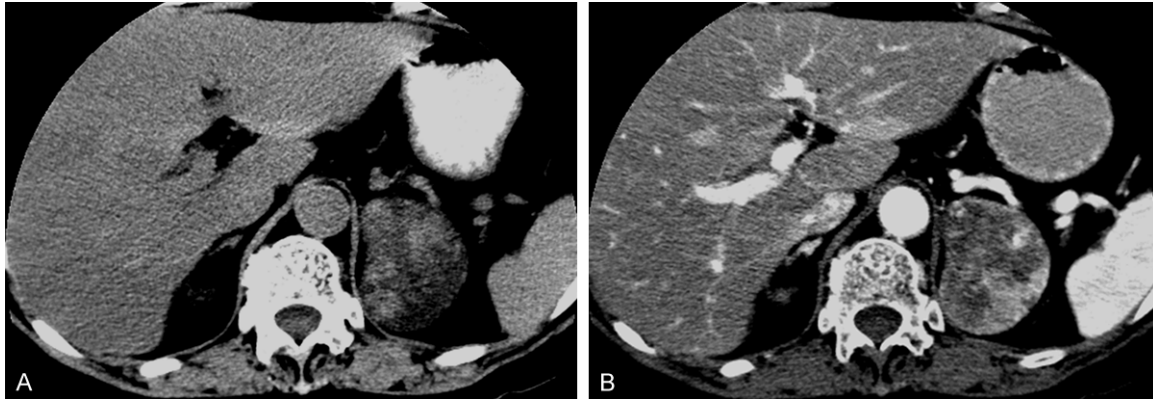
A 44-year-old male with non-functional adenoma of the left adrenal gland. A. The mass shows obviously heterogeneous attenuation on non-enhanced CT. B. The mass presents moderately heterogeneous enhancement after contrast administration.
